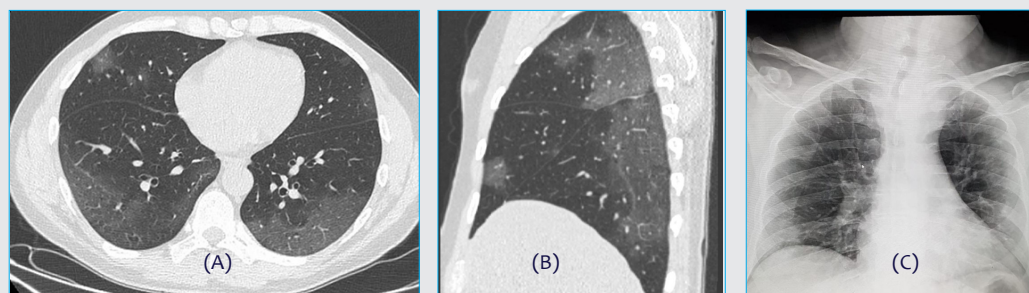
Axial (A) and sagittal (B) sections of a CT scan of the chest of a patient with COVID-19 showing the classic category of COVID-19 (early stage). Patchy and bilateral GGO involving all lobes mainly the lowers. (C) chest X ray of another patient with early COVID-19 shows bilateral and peripheral opacities.
